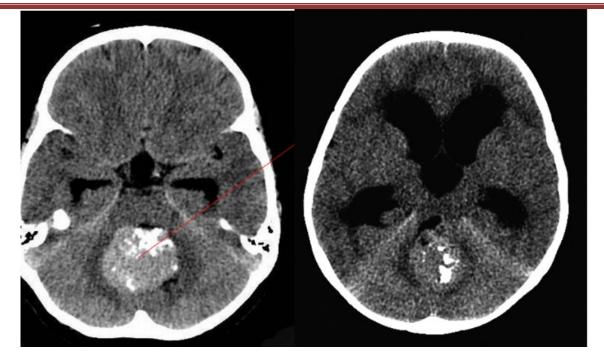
shows on unenhanced CT scan image intratumoral calcifications present.
